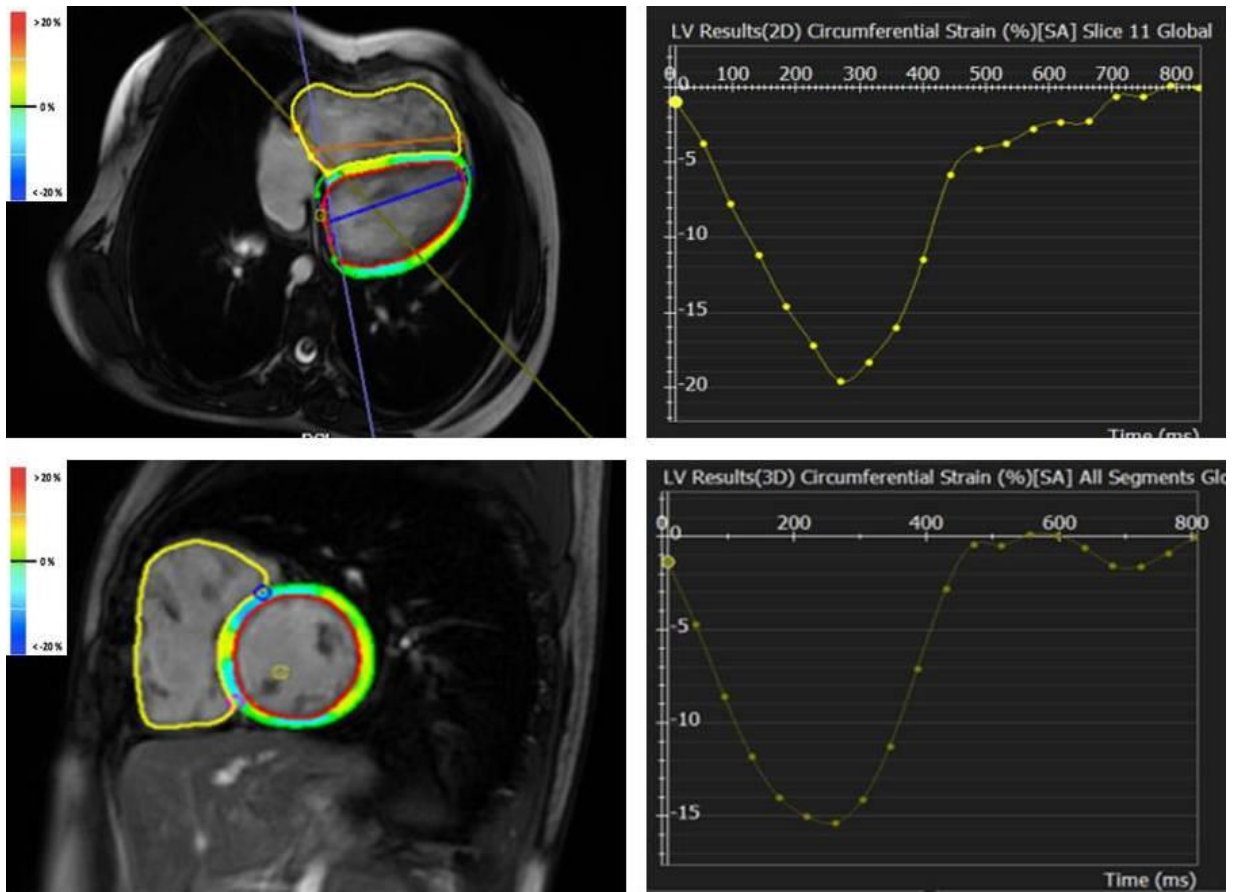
7: Magnetic resonance imaging colored strain analysis of the left ventricle. A four-chamber cine steady-state free precession sequence (upper-left) provides the radial strain curve (upper-right), and a short-axis cine steady-state free precession sequence (lower-left) provides the circumferential strain curve (lower-right). The green line represents the outline of the left ventricular epicardium, while the red line represents the outline of the left ventricular endocardium. The yellow lines in the graphs (left-upper, left-lower) correspond to strain measurements from each ventricle.
